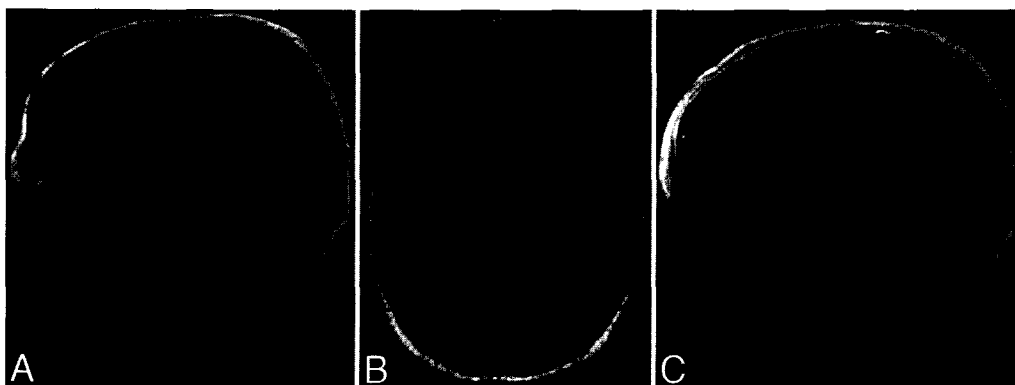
Sagittal contrast-enhanced T1-weighted MR images of the brain in a patient with multicentric glioblastoma, showing right frontal and right parietal ring-enhancing lesions before (A) and after (C) resection. Gross-total resection was achieved via 2 craniotomies in the same surgical session with the aid of cortical mapping and intraoperative MR imaging. A preoperative axial FLAIR image of these same lesions (B) shows no connections between them.
